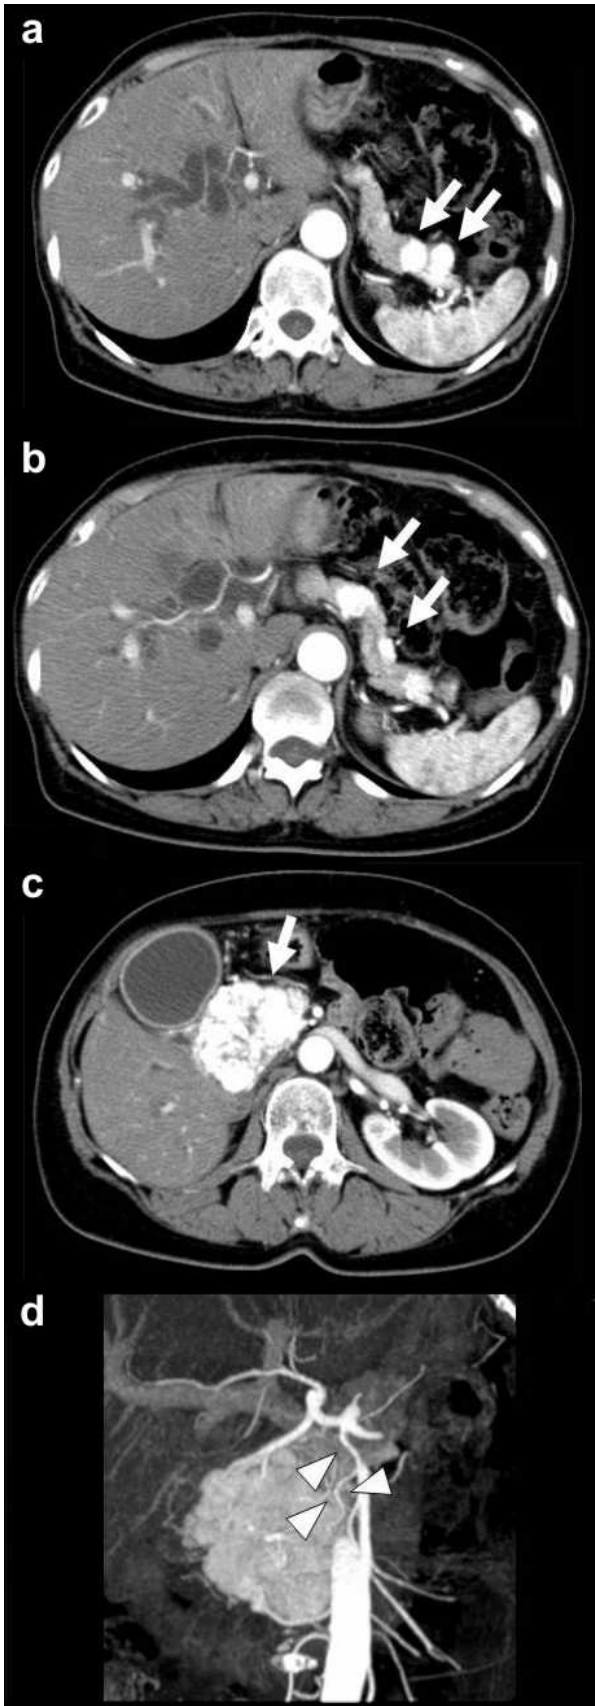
Preoperative computed tomography. Pancreatic metastatic tumors were detected as being demarcated enhanced tumors in the tail (a.) and body (b.) of the pancreas. A very large tumor occupied the entire head of the pancreas (c.). The common bile duct was compressed by the tumor located in the head of the pancreas (d.).
